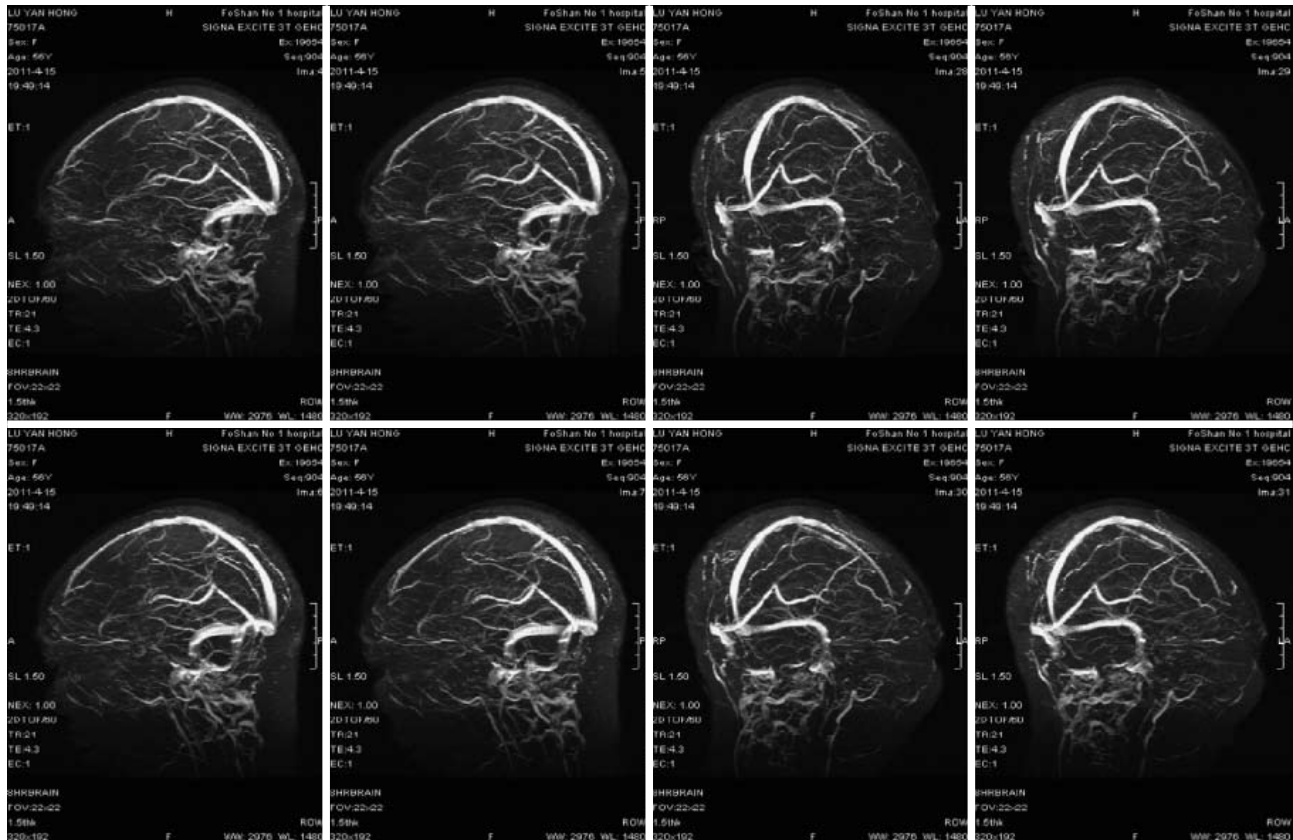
Enhanced brain magnetic resonance imaging and magnetic resonance venography scan of case 1 (2 d after recovery). Mottled lesions of the left parietal lobe, indicating intracerebral microbleeds.
